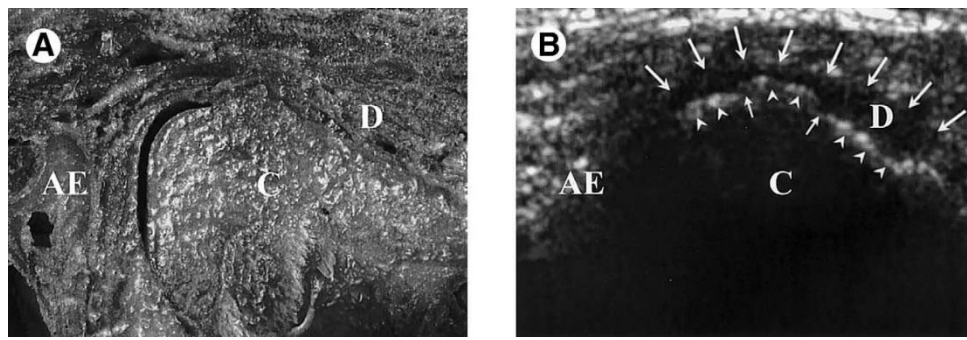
(A) Parasagittal section shows disc disrupted and displaced anteriorly to condyle, and presence of condylar erosion. (AE, articular eminence; C, condyle; D, disc). (B) Longitudinal high-resolution sonography scan (same joint as A) shows anterosuperior TMJ compartment with disc (arrows) anterior to condyle (arrowheads), and presence of condylar erosion (small arrows) (AE, articular eminence; C, condyle; D, disc) (top, anterior; left, superior).^[56]
